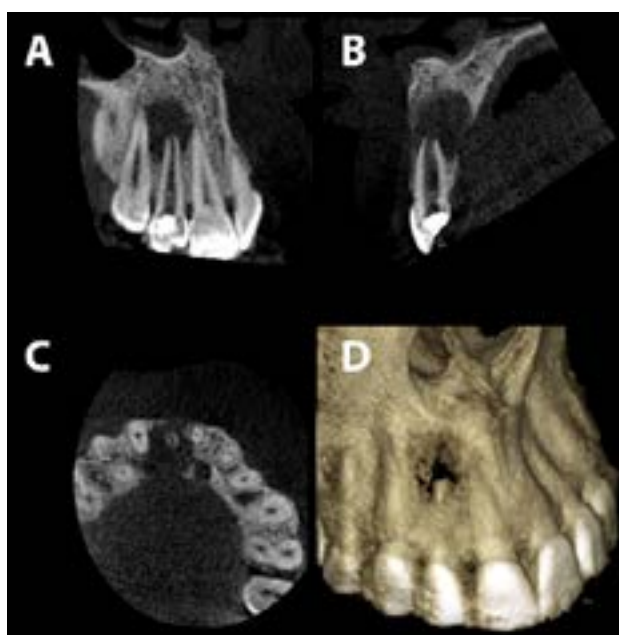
A limited field-of-view CBCT confirming the absence of a natural apical constriction, severe bone loss and perforation of buccal cortical plate: A) Coronal view, B) Sagittal view, C) Axial view and D) three-dimensional reconstruction.
